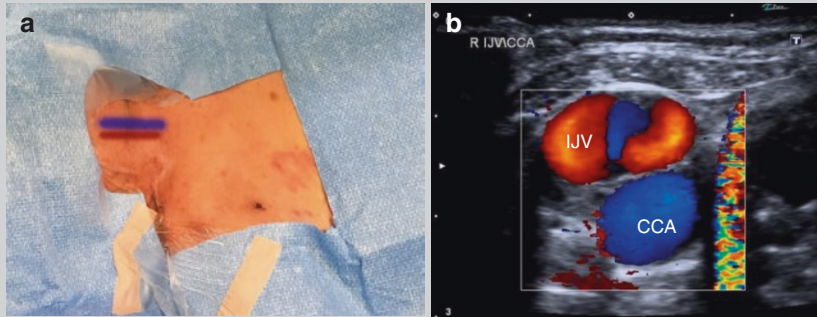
Tunneled haemodialysis catheter insertion. (a) Patient positioned supine with the head turned to the left. A sterile drape has been placed over the right lower neck and upper chest. The approximate positions of the right internal jugular vein (IJV, *blue*) and common carotid artery (CCA, *red*) are indicated. (b) Duplex ultrasound of the neck vessels showing the IJV and CCA. (c) Under ultrasound guidance, the IJV is accessed with a 21 gauge micropuncture access needle (*arrow*). (d) Following access into the vein, a guidewire (*arrow*) is advanced into the IJV, superior vena cava and then into the inferior vena cava. Over the guidewire, serial fascial dilators are advanced through the venotomy site and a peel-away sheath is placed (*arrowhead*). (e) The tunneled dialysis catheter is passed subcutaneously through a “tunnel” formed by blunt dissection until its tip emerges at the level of the venotomy. (f) The catheter tip is then passed through the sheath until the entire catheter, except the access hubs, is internalised. The venotomy site is closed with a suture and the catheter is anchored to the skin with sutures. (g) Final position of the catheter tip within the right atrium (*arrow*) is confirmed on fluoroscopy
